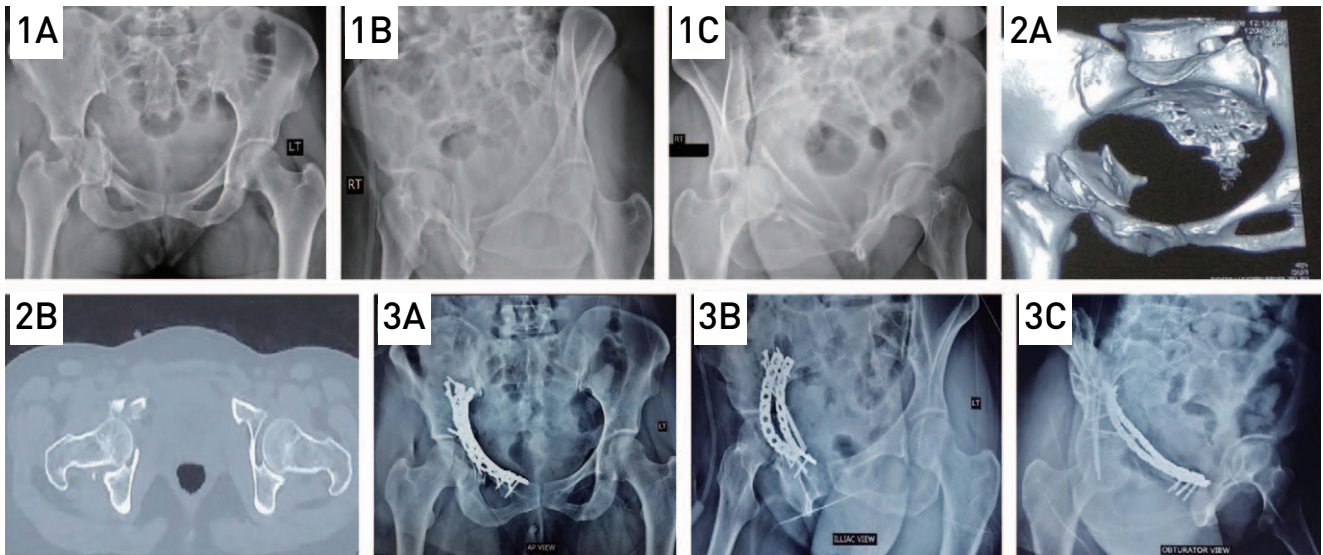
A 38-year-old female sustained pelvic trauma in a road traffic accident. Preoperative x-rays and computed tomography (CT) scan show a low anterior column and posterior hemitransverse fracture with anterior wall and quadrilateral plate displacement. Postoperative images show fixation with a suprapectineal plate plus infrapectineal buttress plating for a quadrilateral plate and antegrade posterior column screw via a small lateral window. (1A-C) Preoperative x-ray pelvis AP view, iliac oblique, and obturator oblique views. (2A, B) CT scan axial view and 3D reconstruction view. (3A-C) Immediate postoperative x-ray pelvis AP view, iliac oblique, and obturator oblique views.
